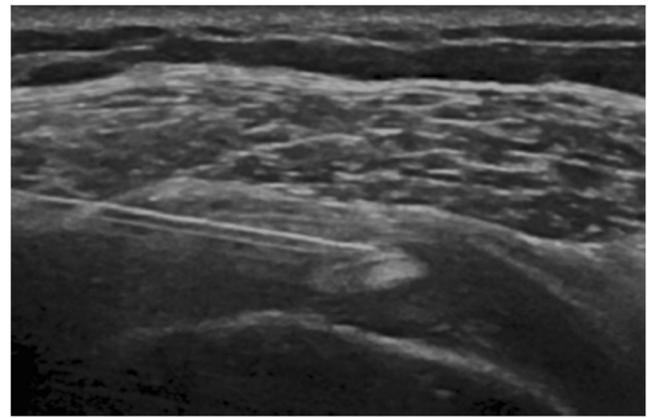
A transverse ultrasound image of the rotator interval with the long head of the biceps tendon (*BT*) at the centre of the image. The superior glenohumeral ligament (*SSp*) is anterior to the biceps tendon and the CHL forms the roof of the interval superiorly. The *SSp* lies laterally and the *SSc* lies medially. The *asterisk* indicates the target point of the needle for targeted rotator interval injection
